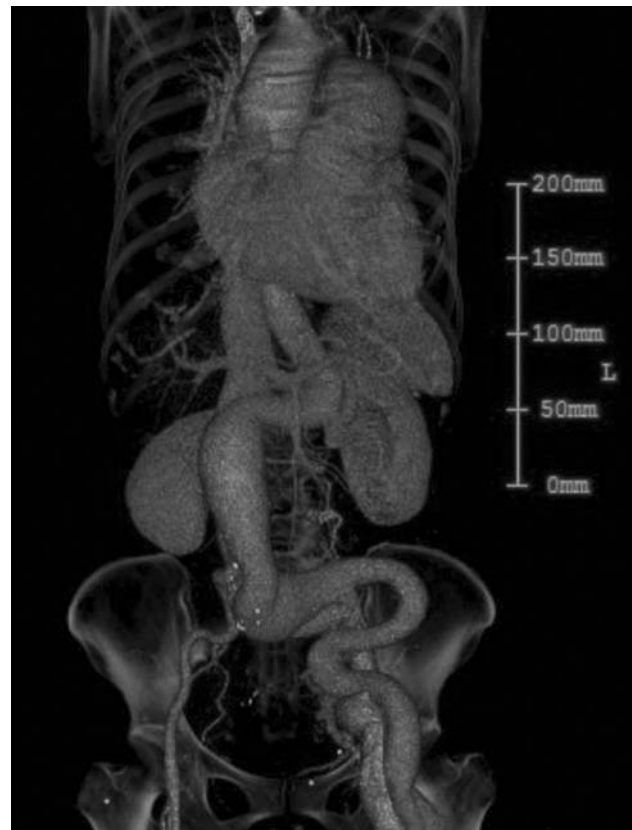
Computed tomography angiography of the trunk. Dilatations of the ascending aorta, abdominal aorta, and pulmonary artery are present. The abdominal aorta is severely tortuous below the renal arteries. The arteries from the left common iliac artery to the left popliteal artery are also tortuous and dilated
